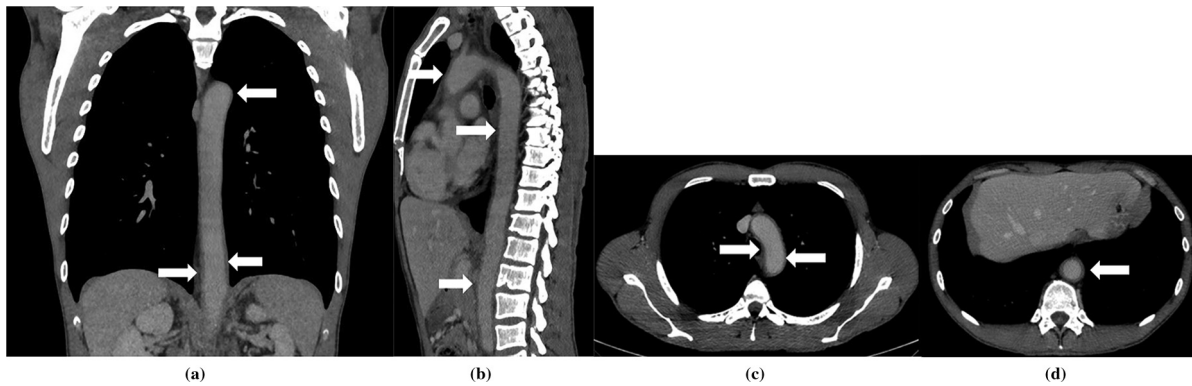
a-d. Thoracic and abdominopelvic CT scan, showing arterial wall thickening with intravenous contrast uptake increase. (a) Coronal image, descending aorta (arrows). (b) Sagittal image, ascending aorta, arch, thoracic, and abdominal aorta (arrows). (c) and (d) Arterial arch and abdominal aorta, respectively (arrows in axial images).
